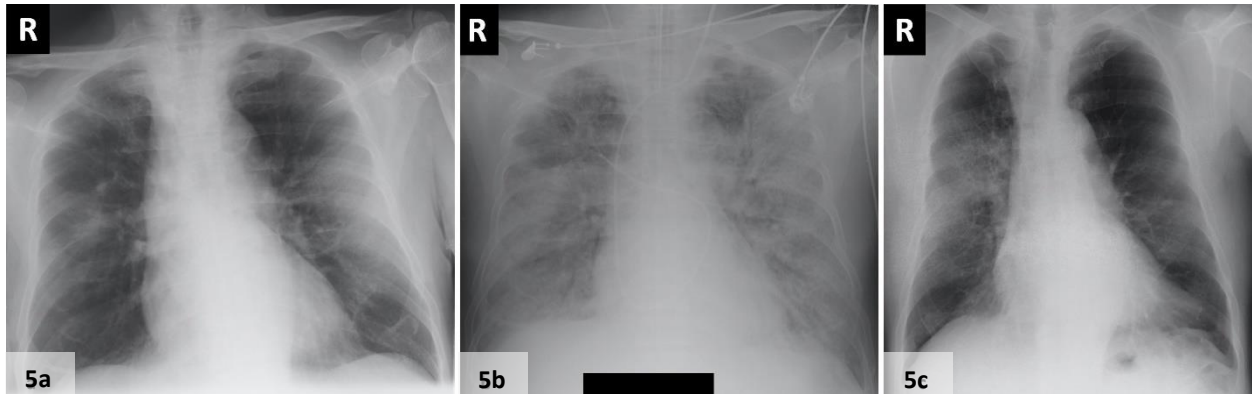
(a & b) A 72-year-old woman diagnosed with SARS in 2003. (a) Initial chest radiograph obtained on Day 5 of symptoms shows bilateral lung consolidation in the right middle as well as left middle and lower zones, which appear predominantly peripheral in location. (b) Follow-up radiograph performed 13 days later shows worsening lung changes with diffuse bilateral lung consolidation, in keeping with the picture of acute respiratory distress syndrome. The patient succumbed to the disease one day later despite intensive care support. (c) A 68-year-old man with SARS admitted in 2003. Chest radiograph taken on Day 6 of symptoms shows a focus of unifocal ill-defined consolidation with concomitant reticular markings in the right middle zone. The patient was discharged well after 2 weeks.
